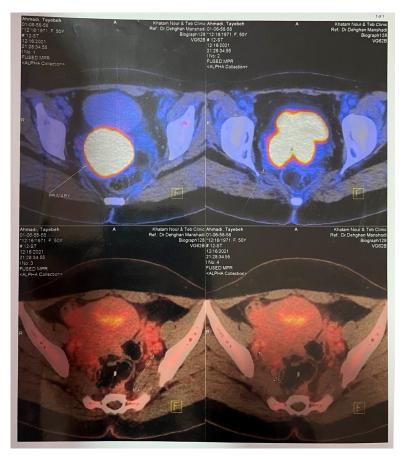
The results of PET CT
